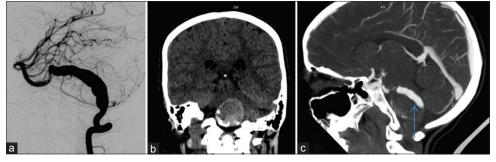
Thrombus detection in computed tomography angiography and digital subtraction angiography. (a) Digital subtraction angiography image in lateral view showing fusiform aneurysm involving the entire V4 segment of the right vertebral artery, (b) Noncontrast computed tomography of the same patient showing round hyperdense lesion with calcification in its inferior aspect (c) Sagittal maximum intensity projection image of the same patient showing large-rounded aneurysm of the right vertebral artery filled with thrombus and contrast visualization only in upper aspect (arrow)
